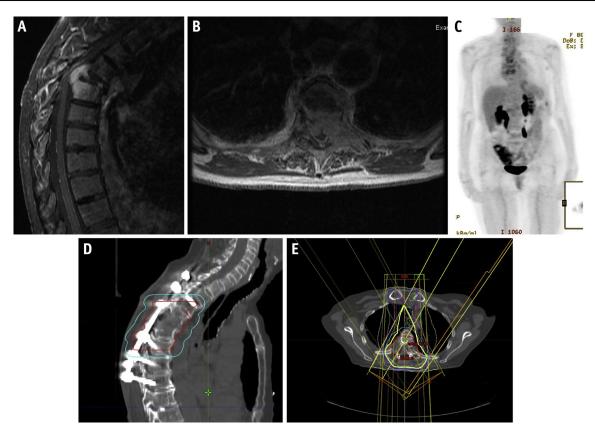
A 79-year-old woman with acute back pain and rapidly progressive leg weakness with urinary retention was found to have spinal cord compression at the T5 level on magnetic resonance imaging. T1-weighted sagittal (A) and axial (B) images revealed near total destruction of the T5 vertebral body, with kyphotic deformity, and a soft tissue tumor extending to both T4 and T6 vertebrae. Enhancing soft tissue tumor at T5 compressed and displaced the spinal cord. Urgent surgery was performed, with T5/6 corpectomy, laminectomy, and fusion from T2 to T8. Pathology revealed a plasma cell neoplasm. A fluoro-deoxyglucose—positron emission tomography scan showed postoperative changes from T2 to T8, and no other sites of fluoro-deoxyglucose-avid disease (C). Serum M-protein was detected with IgG of 789 mg/dL, and a bone marrow biopsy showed 12% clonal plasma cells. A diagnosis of multiple myeloma was established. Postoperative radiation therapy was given to offer optimal local control, and the clinical target volume (red) was based on the preoperative extent of the local disease on magnetic resonance imaging, with a 1-cm isotropic expansion for the planning target volume (light blue) (D). Note that the full extent of the surgical hardware need not be covered. The prescribed dose was 30 Gy in 10 fractions with a 3D conformal technique (E), as a palliative treatment. The patient subsequently started on systemic chemotherapy. (A color version of this figure is available at www.redjournal.org.)
